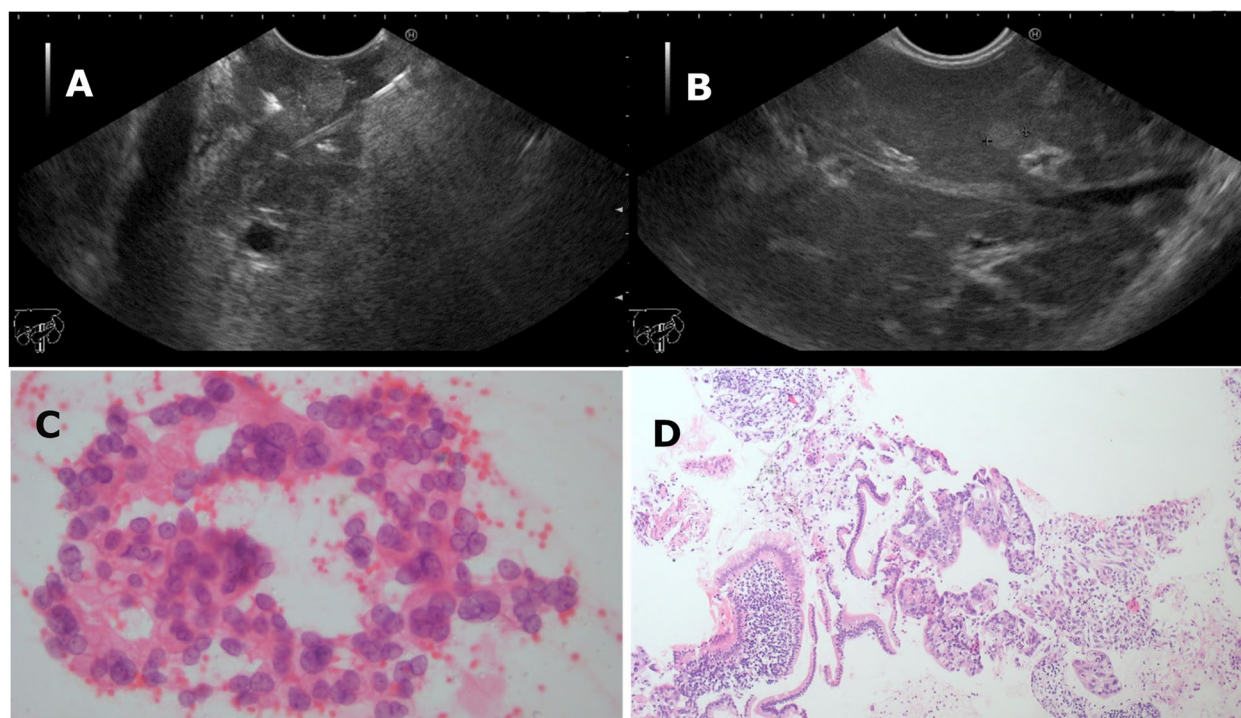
Endoscopic ultrasound images showing pancreatic head cancer (A) and liver metastatic lesions (B). Cytopathological examination of EUS-guided fine needle aspiration: smear showing multiple aggregates of atypical polygonal epithelial cells with large hyperchromatic nuclei with irregular nuclear membranes and occasional small distinct nucleoli (C), cell block revealing multiple strips of atypical epithelial cells with glandular formations exhibiting moderate atypia and pleomorphism (D)
